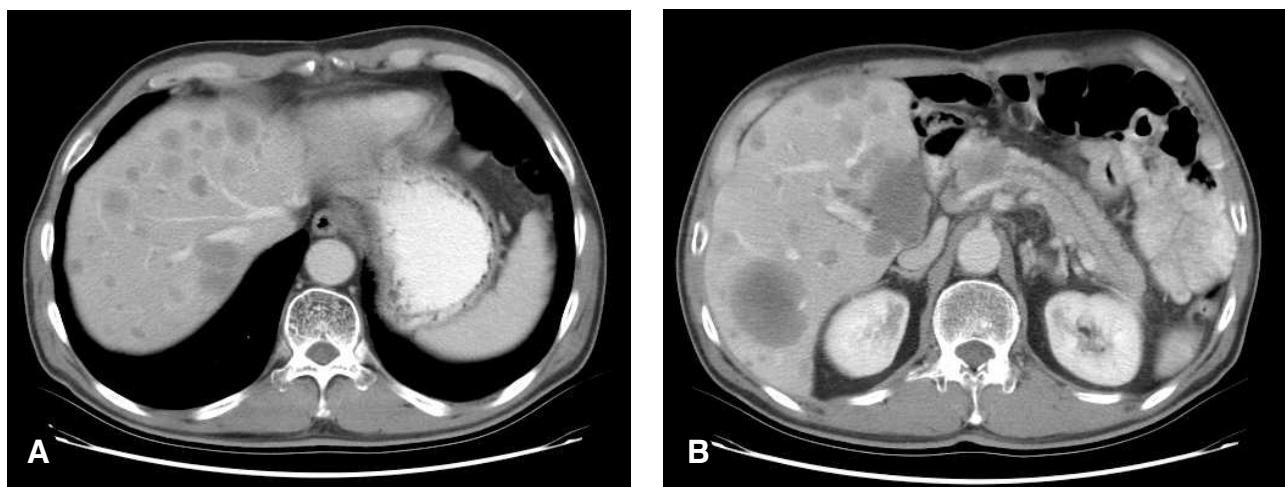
CT scan of the abdomen. (A and B) Multiple variable-sized metastatic nodular lesions are seen in the entire liver.
